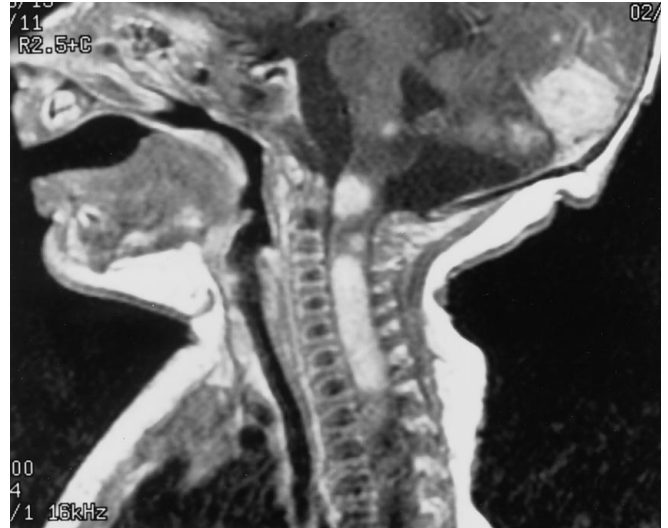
Gadolinium-enhanced sagittal T1-weighted image (TR/TE, 500/14) demonstrates expansion and enhancement of the cervical spinal cord, as well as enhancing lesions in the right occipital lobe and brainstem
